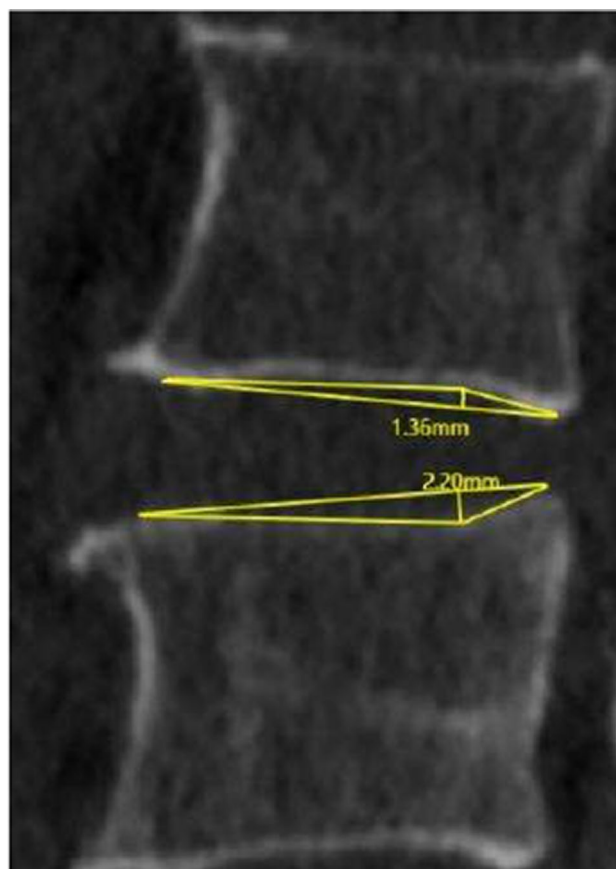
Preoperative lumbar CT showing the measurement of endplate flexion depth at L4-5 segments
